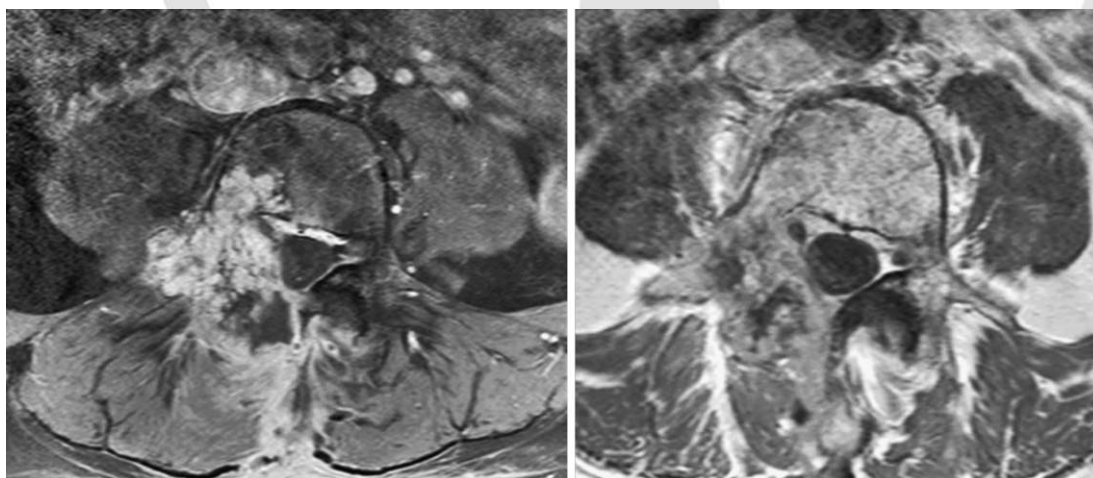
Postoperative axial MRI images (both T₁ with contrast) of L4. Left image shows status one month after operation with decompression of nerve roots and the dural sac but still considerable enlargement and enhancement of the right side of the vertebral body L4 and intraspinal and paravertebral region. Right image shows status 24 months after local radiosurgery: stable decompression of the nerves and the dural sac without radiological signs of persistent inflammation.
